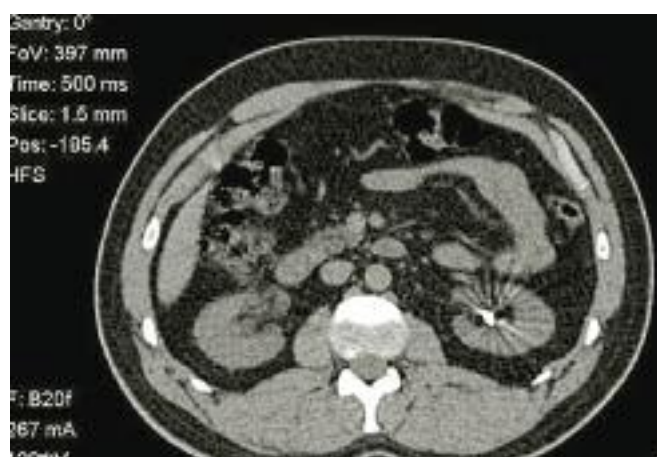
CT scan showing the atypically dense kidney stone with sparkling artefacts.
